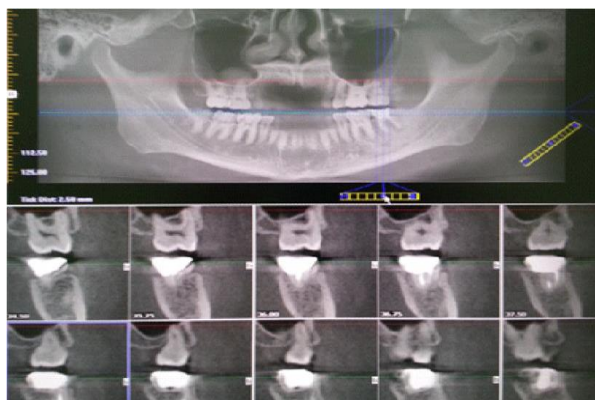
Figure – IV & V: Computed Topography of Bitewing
